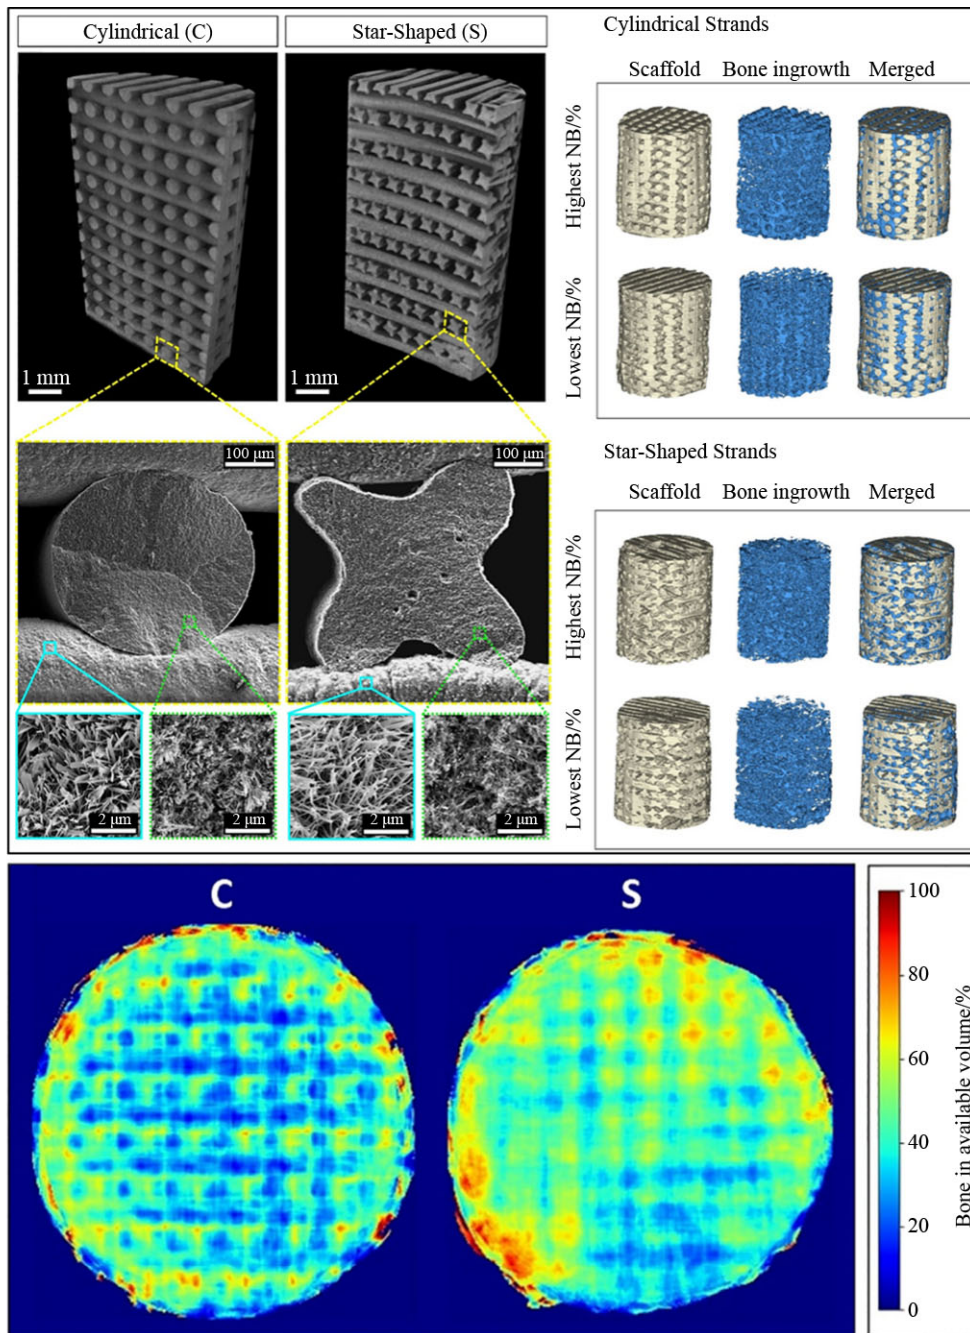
Scaffold observations by μ CT and SEM imaging (upper panel) along with cumulate mapping of the formed new bone (NB) (lower panel). Reproduced with permission from Ref. [118] (Copyright 2022, Elsevier).
